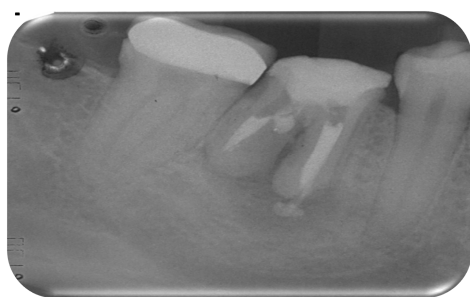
Pre-treatment X-ray
